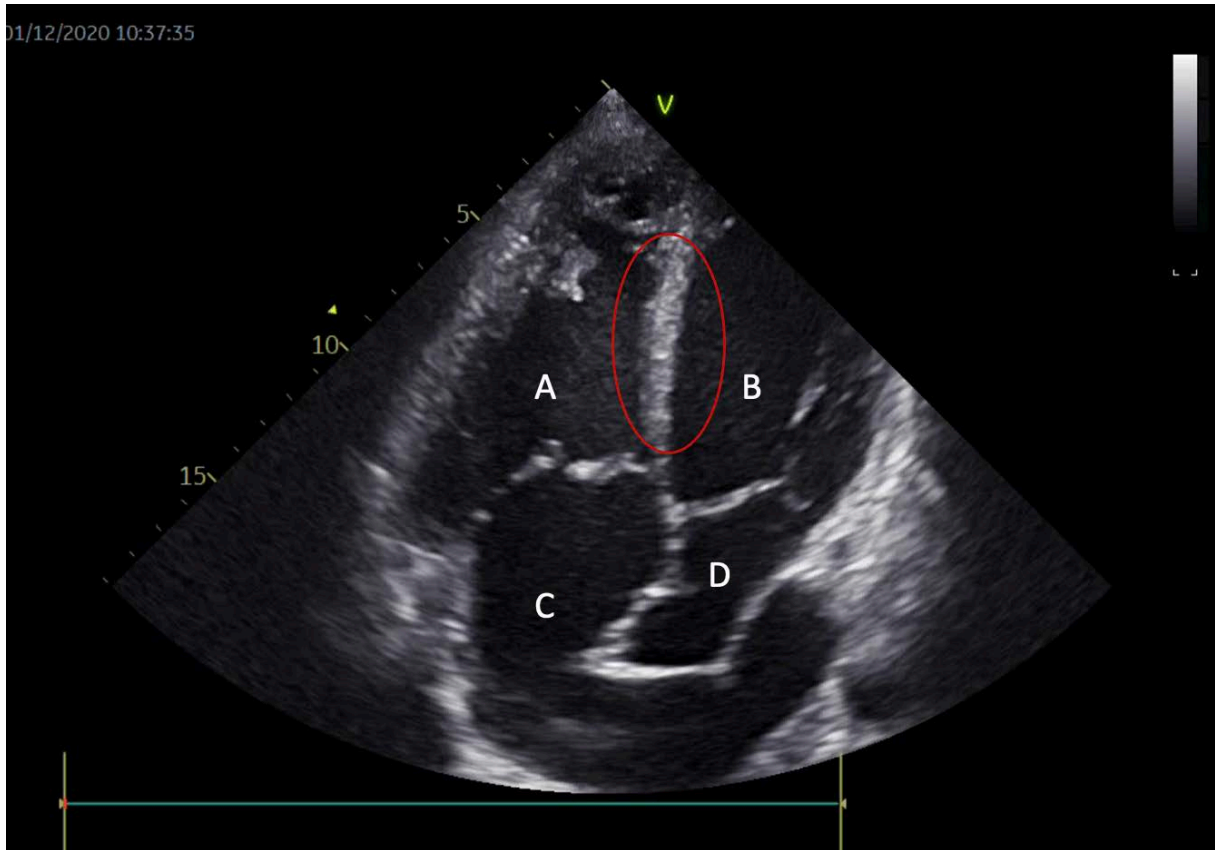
Echocardiographic image of the patient during admission. Apical four-chamber view showing the enlargement of the subpulmonary ventricle and features of increased pressure in the pulmonary circulation as bulging of the interventricular septum towards the systemic chamber (marked with a red circle). A. Systemic right ventricle. B. Subpulmonary left ventricle. C. Systemic baffle. D. Pulmonary baffle
